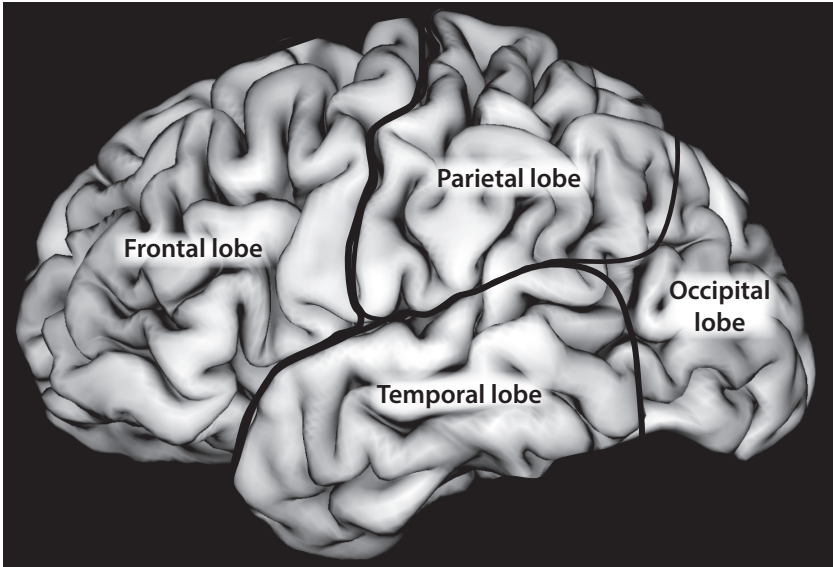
The lobes of the brain, outlined on an image of the surface of my brain that was generated from MRI data.
